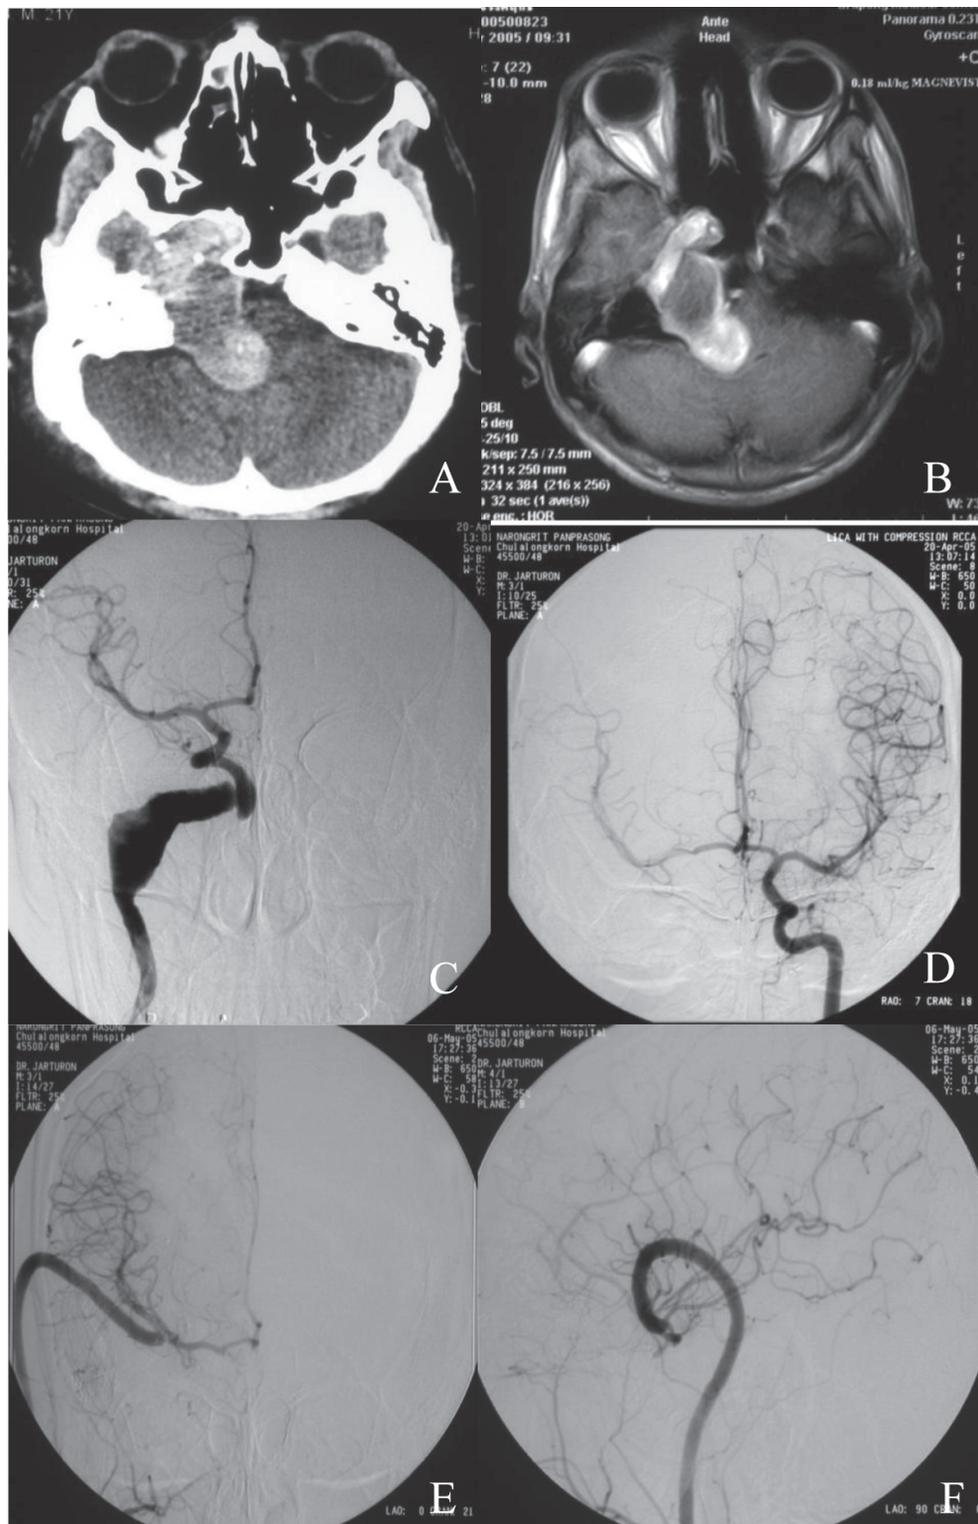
A 21-year-old male (case NO.9) presented with diplopia due to Rt. ophthalmoparesis. A contrast CT scan (A) and post-gadolinium T1WI MRI (B) revealed a inhomogeneous contrast enhancing mass involved Rt. Petrous, temporal fossa and CP angle region. DSA showed a fusiform giant right ICA aneurysm (C) and poor cross-flow from Lt.ICA through AcoA and minimal retrograde flow from posterior circulation through Rt.PcoA (D). Rt. ECA-M1 bypass and trapping was performed. Post-operative DSA (E,F) showed a well obliterated aneurysm and patent bypass graft. The ophthalmoparesis was improved at immediate postoperative period and completely recovered at 2-month follow-up.
